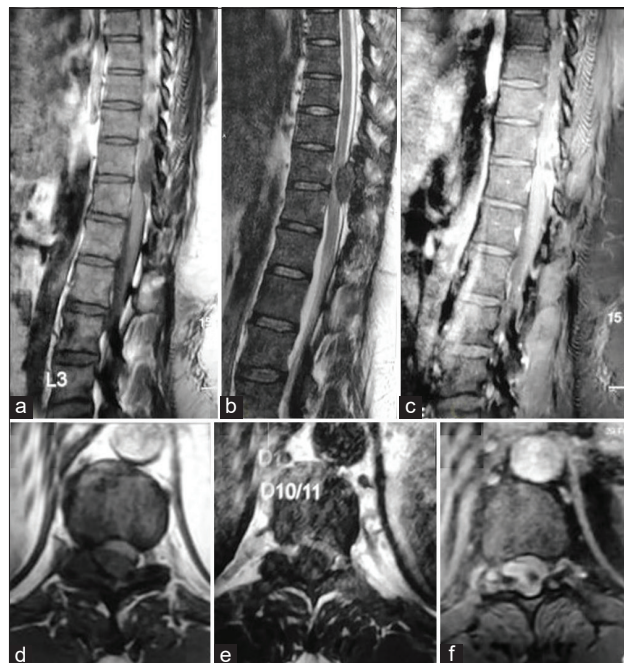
Magnetic resonance imaging of thoracic spines. (a) Sagittal plane T1-weighted section. (b) T2-weighted section. (c) Contrast-enhanced T1-weighted section. (d) Axial plane T1-weighted section. (e) T2-weighted section. (f) Contrast-enhanced T1-weighted section. The images show an oval extramedullary intradural mass lesion (3.0×1.6 cm in size) at T10-11 lying to the right posterolateral aspect of the spinal cord. The lesion shows heterogeneous low signal intensity on T2W images and iso- to low signal intensity on T1W images with moderate heterogeneous enhancement.
